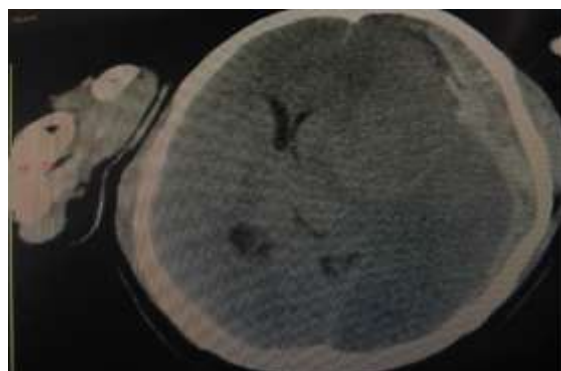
Brain CT of Case 3 showing left frontotemporoparietal SDH with mass effect.
